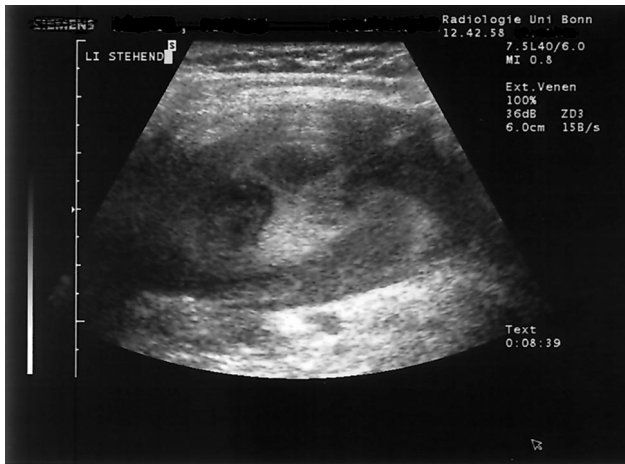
Duplex sonography of the left popliteal venous aneurysm with the patient in upright position. Extremely slow flow was demonstrated within the lumen of the aneurysm.
